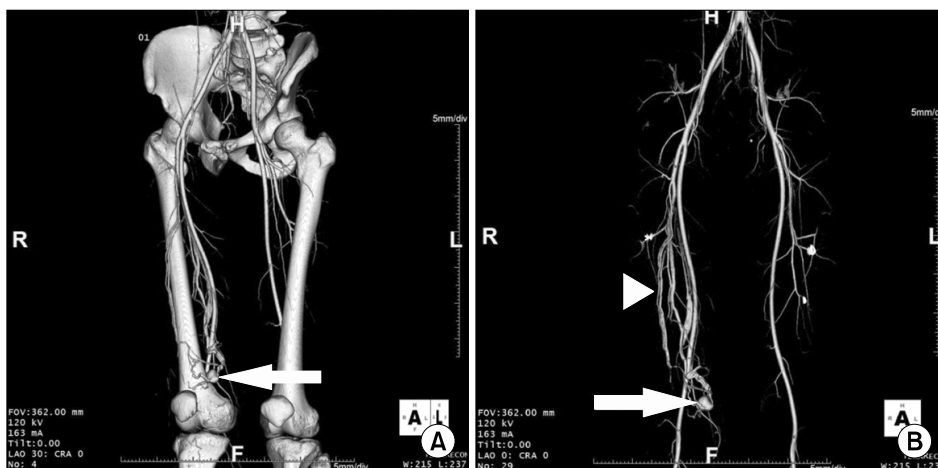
Computed tomographic angiogram with three-dimensional reconstruction. (A) A pseudoaneurysm (solid arrow) above the right knee is shown. (B) A pseudoaneurysm (solid arrow) with venous enhancement (arrowhead) in the arterial phase. The arterio-venous fistula was accompanied on the pseudoaneurysm in this case.
